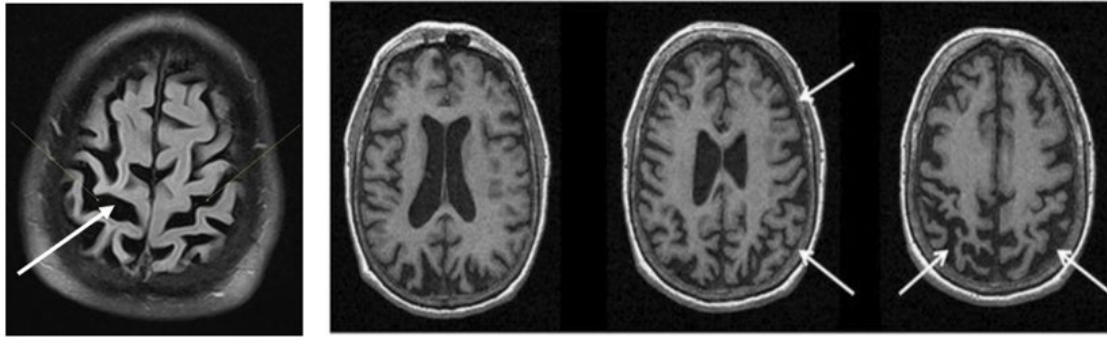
MRI Image, axial T1-weighted sequence, of a patient diagnosed with CBD, confirmed by pathology. The series of axial T1-weighted slices reveals bilateral, asymmetric fronto-parietal cortical retraction, predominantly affecting the right cerebral hemisphere (white arrows) [16].
